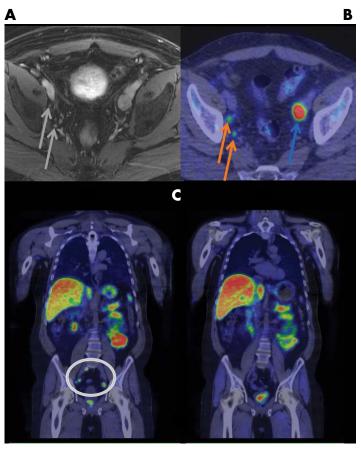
MRI (A) and choline PET/CT (B) in a patient with prostate cancer recurrence (PSA 3.3) show an enlarged left external iliac lymph node with choline uptake (blue arrow) and small right external iliac and internal iliac lymph nodes (grey arrows) with choline uptake (orange arrows). The small right nodes are only considered abnormal on choline PET/CT. PET showed more extensive disease than MRI. After treatment (C), all nodal disease (circle) shows resolution (right image) and the PSA is <0.01.
